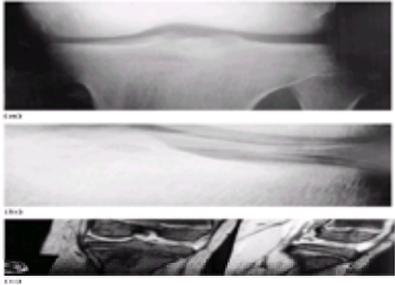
Discoid meniscus. (a) The plain radiograph shows widening of the lateral compartment and often dishing of the lateral tibial plateau due to the mass effect of the enlarged meniscus. (b) On arthrography, instead of the normal triangular shape of the meniscus, its internal aspect is elongated and expanded. (c) The MR scan of a discoid meniscus shows the expansion of the meniscus, but also increased signal in it. This is extensive and presumably indicates widespread internal degeneration of the meniscus.
